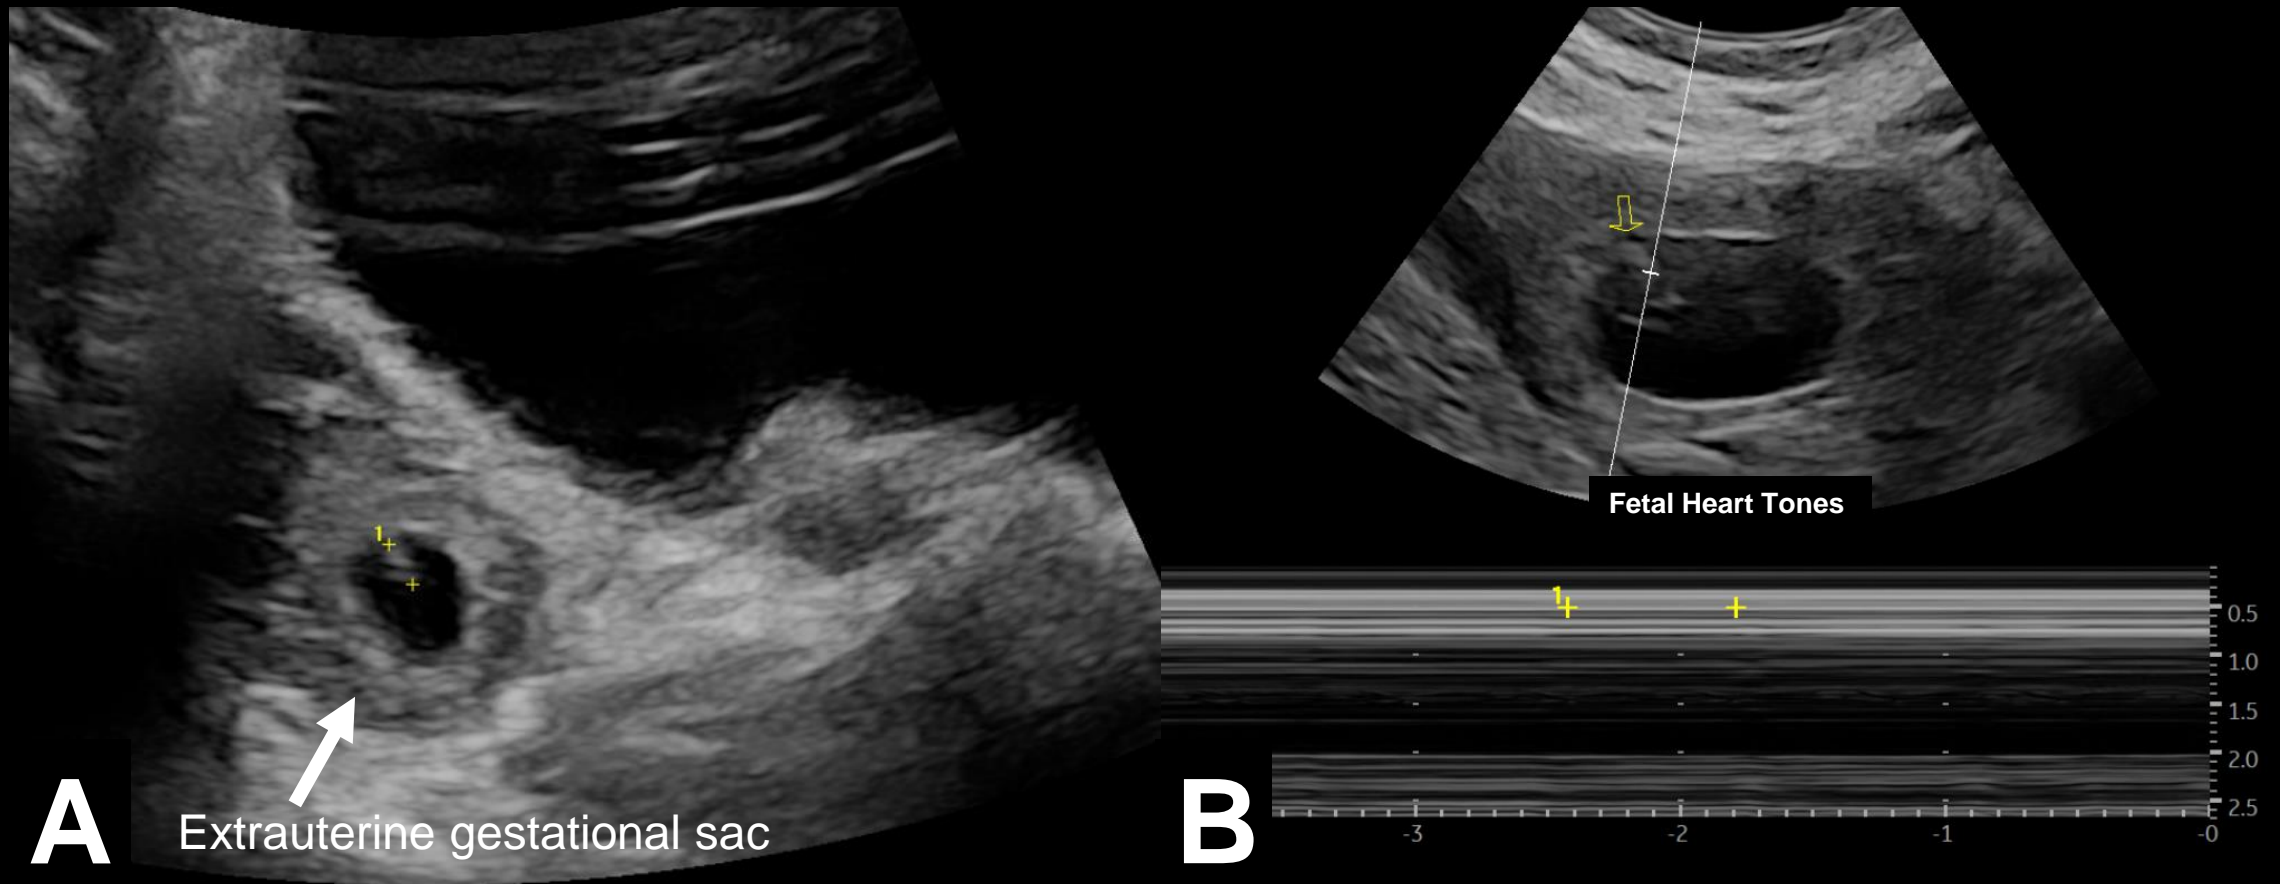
Transabdominal images of the extrauterine adnexal located gestational sac (A). The sac contains a fetal pole with a slow fetal heart tone appreciated on ultrasound M mode (B).
